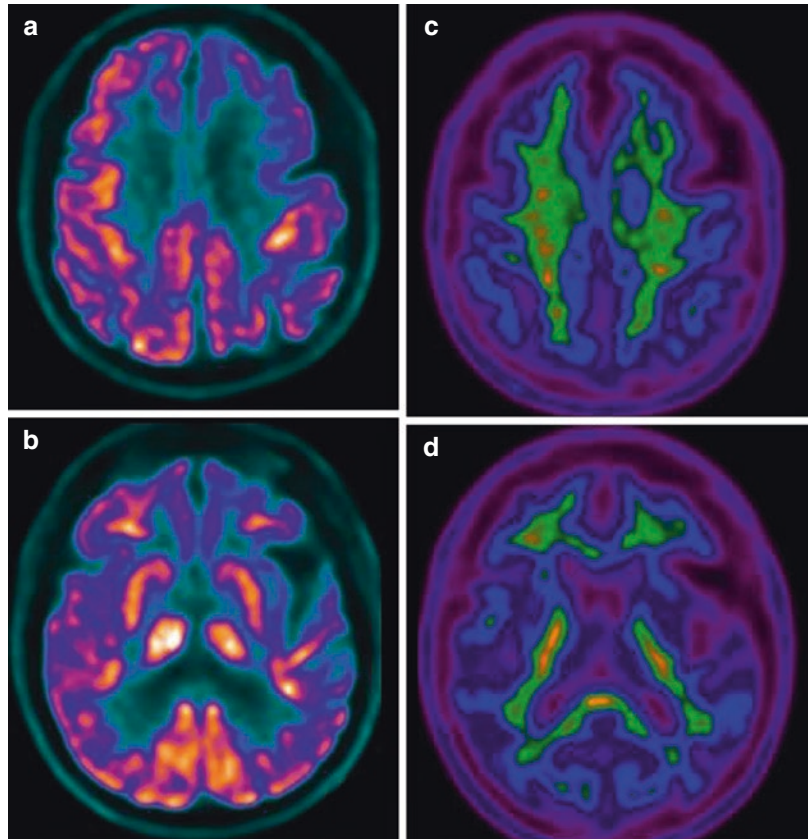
A 66-year-old male patient was examined for clinical suspicion of Alzheimer’s disease with ^{18}F -FDG and ^{18}F -flutemetamol PET/CT scans. Both scans confirmed diagnosis. In the left panel, axial ^{18}F -FDG PET views in different color scales show deficit of glucose
